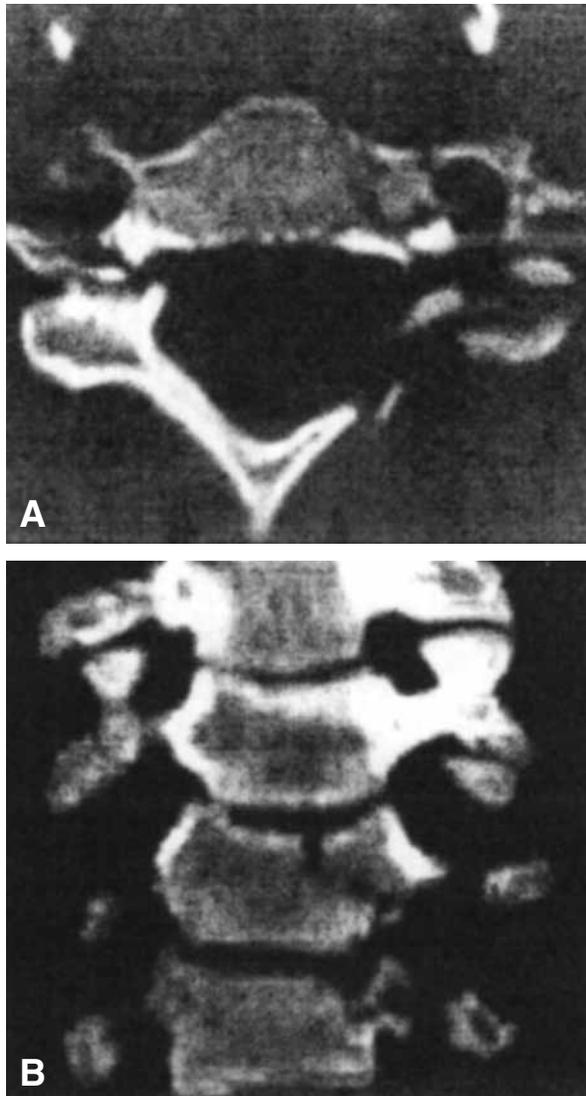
CT scan images of a 26-year-old man sustaining a complex C6-fracture during mountain-biking. He also had a zygomatic fracture on the right side and a fracture of the nose. Transversal sectioning of the neck (A) and then secondary reconstruction of the frontal (B) and lateral planes (C) are shown.
